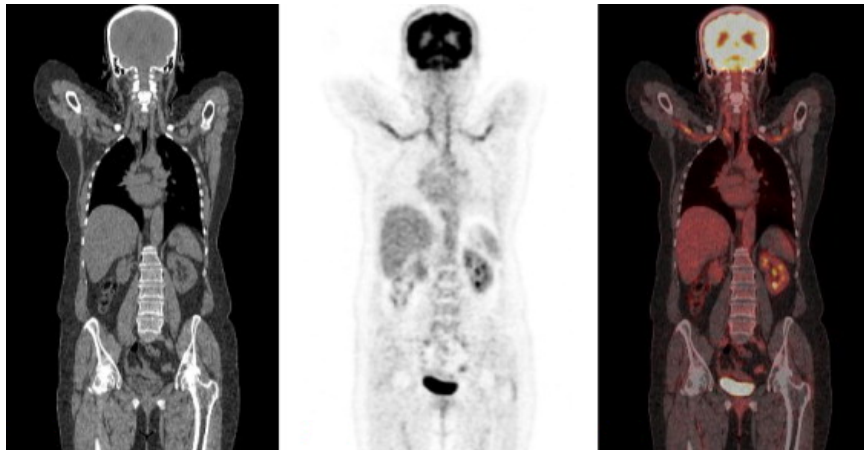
From left: CT, PET and PET/CT images reproduced with permission from [79]. Bone is resolved with high contrast and signal intensity on CT due to its large attenuation factor.
